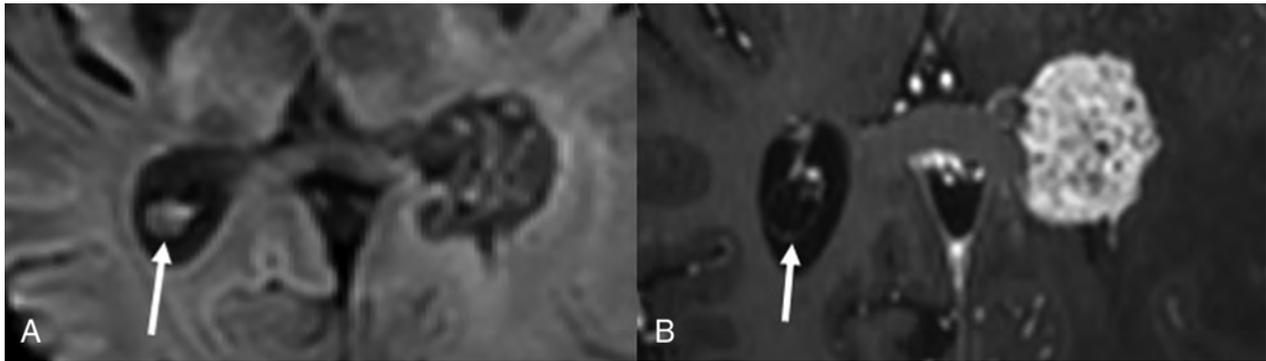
Xanthrogranuloma and choroid plexus metastasis. Axial DWI (A) and postgadolinium T1-weighted (B) MR images of a 56-year-old woman with metastatic renal cell carcinoma. Images demonstrate a cystic lesion centered within the right choroid plexus glomus, which demonstrates increased DWI signal but no central enhancement (arrow), consistent with a xanthrogranuloma. This finding is in contrast to the solidly-enhancing lesion centered within the left glomus, consistent with a hypervascular metastasis.
